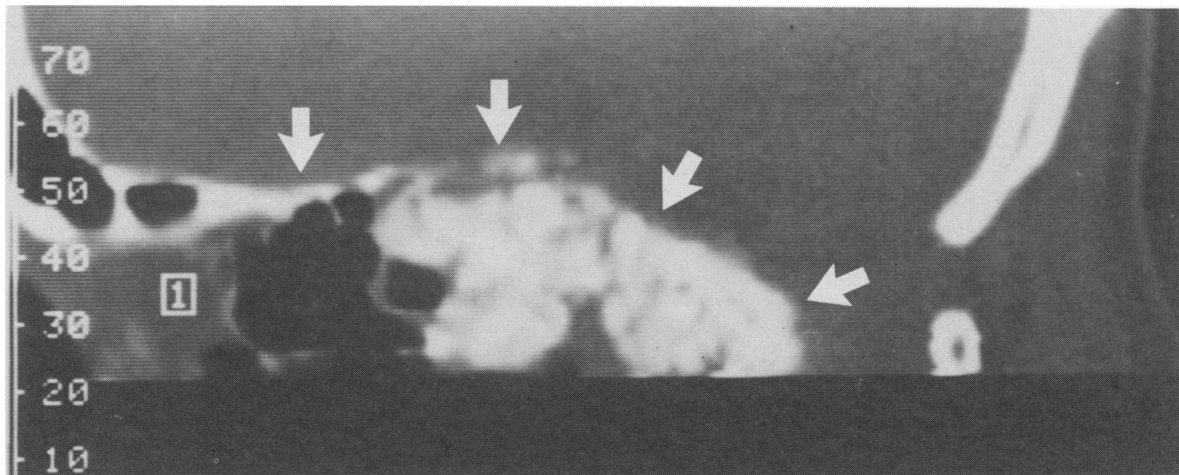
CT scan of a metastatic lesion involving the whole of the clivus which was radically excised by the transoral route, prior to radiotherapy.
